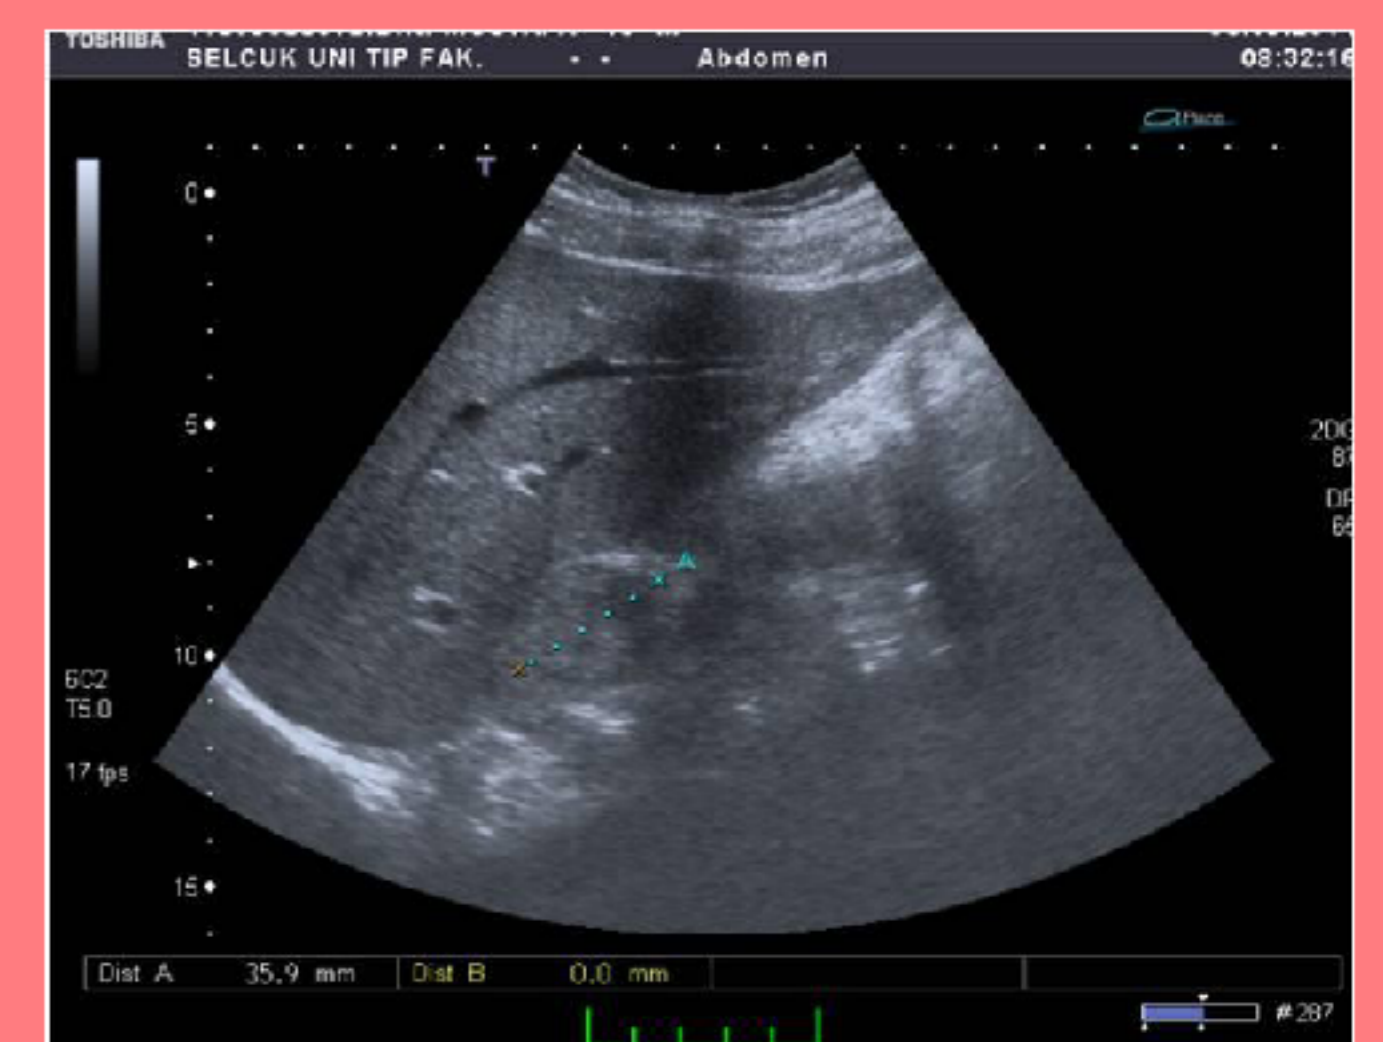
Ultrasonography showing left adrenal mass
